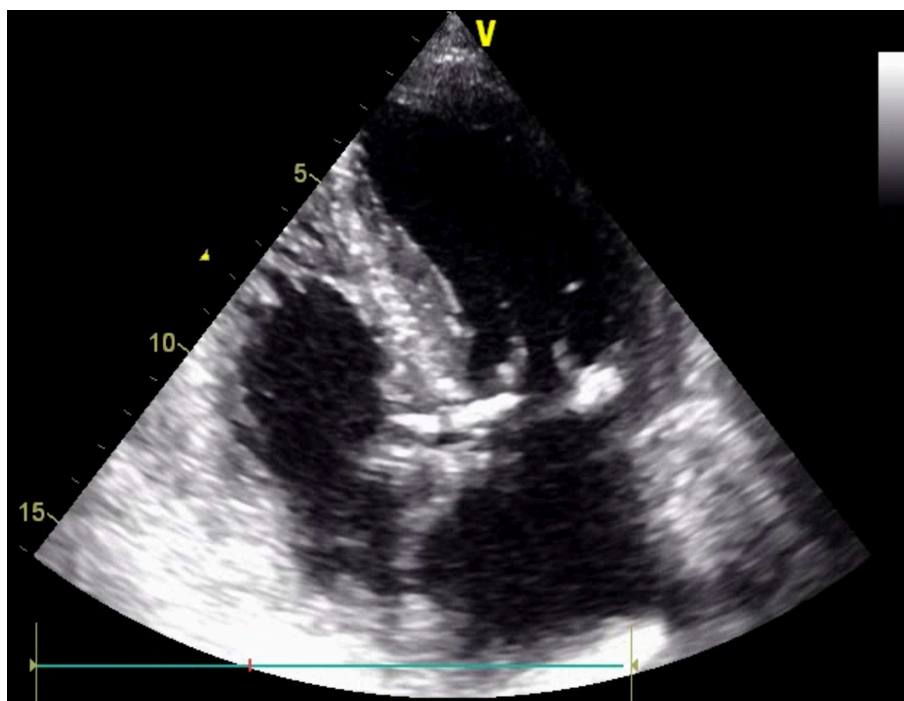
Transthoracic echocardiography (TTE); apical 4-CH view. Mitral annular calcification (MAC).
